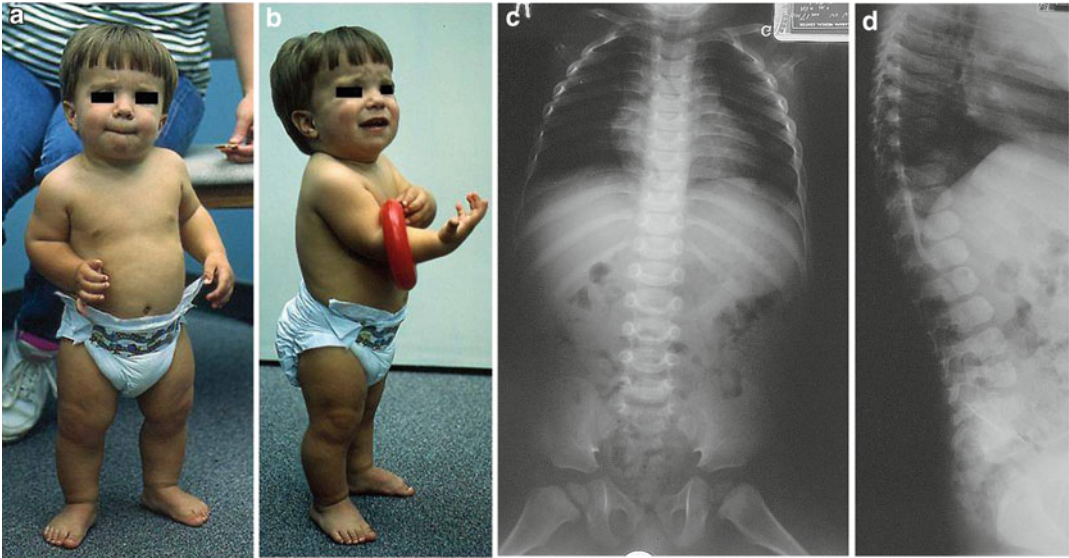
(a–d) A young child affected with hypochondroplasia showing mild short stature and mild rhizomelic shortening of the extremities. Radiographs showed unchanged lumbar interpedicular distance
